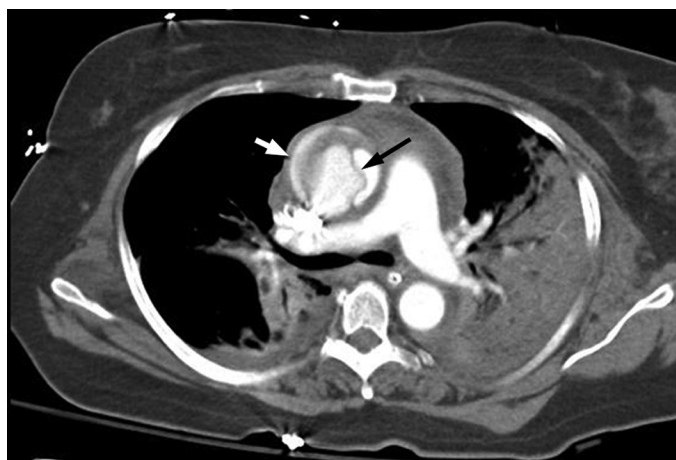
FIGURE e57-23 Contrast-enhanced CT scan of a patient who progressed 3 days after acute type A IMH (MRI of the patient in [Fig. e57-22](#)) to classic type A aortic dissection (*black arrow*) with aortic rupture and hemopericardium (*white arrow*).
